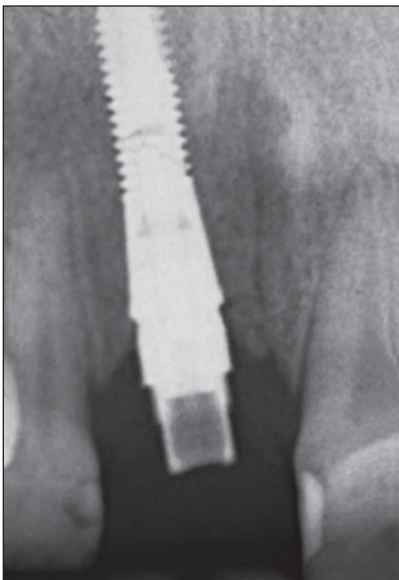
Radiographic evaluation of the implant-bone relationship at the time of implant placement.
